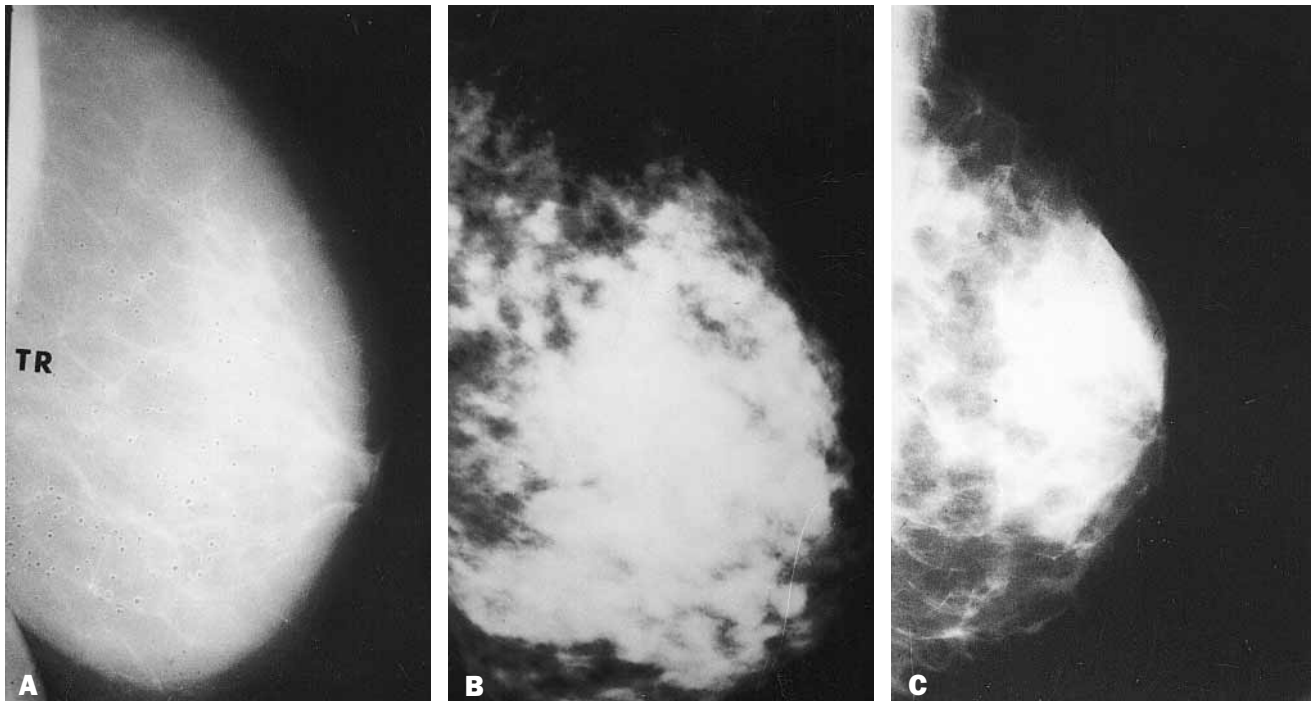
Mammographic evaluation of candidates for breast reduction with the use of ultrasound-assisted lipoplasty (UAL). A, A typical fatty breast. This patient is an ideal candidate for UAL. B, Fibrotic glandular tissue is a contraindication for UAL. C, Fibrotic mixed tissue. This patient is a candidate for UAL of the posterior upper and lower cone.
